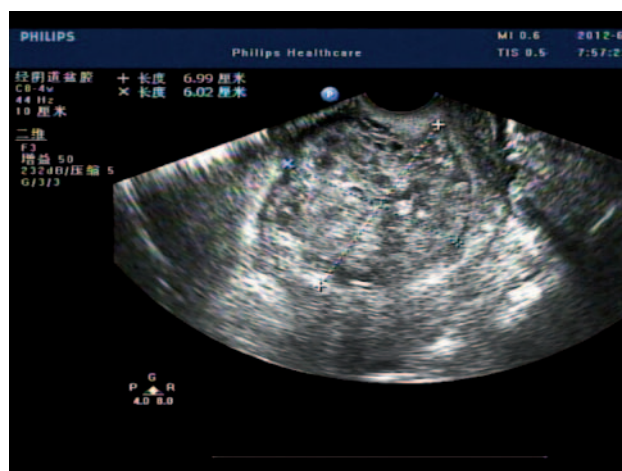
Ultrasonography image one week after UAE.
